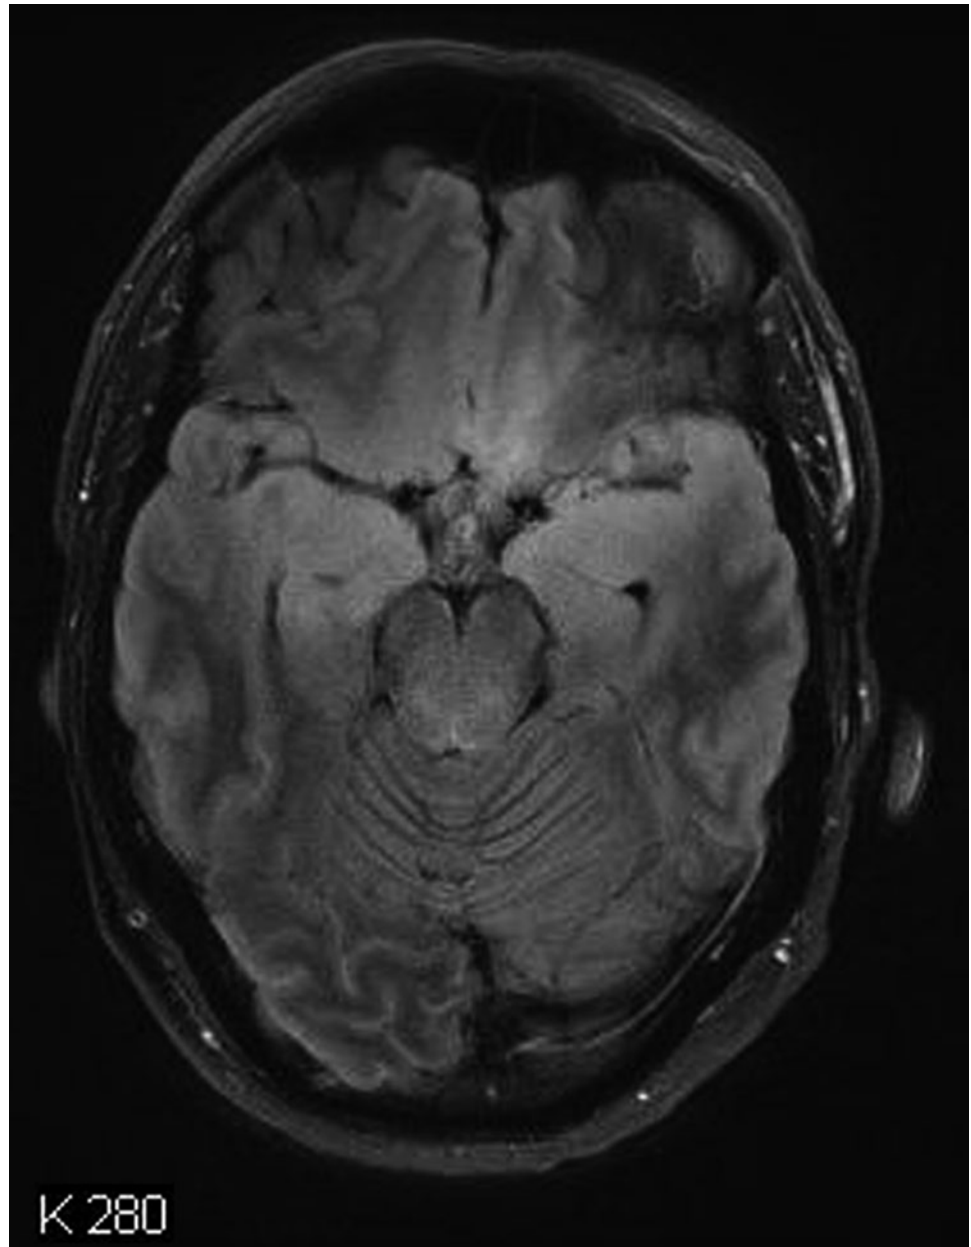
In high-grade gliomas as in this anterior callosal GBM, edema is usually large and the tumor borders tend to be very indistinct (a: T2-weighted MRI). Enhancement (b) can vary but is usually
